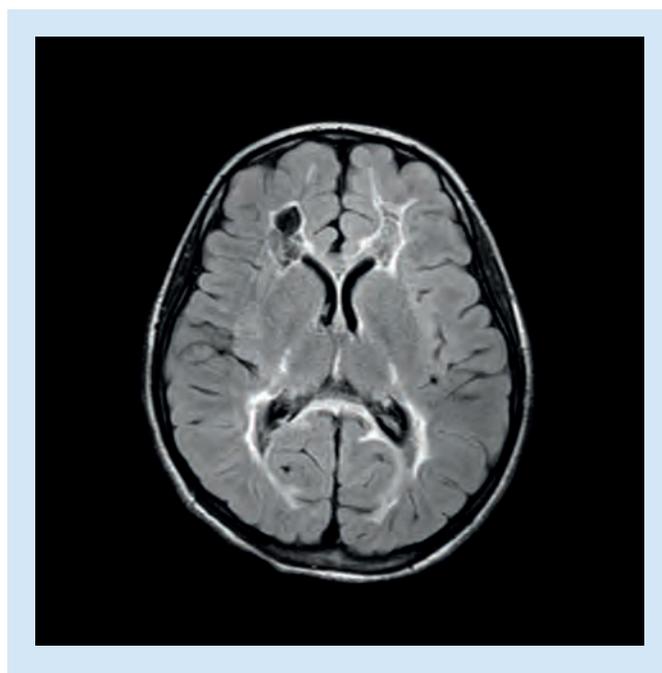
MRI in cystic leukodystrophy (fluid-attenuated inversion-recovery image).
